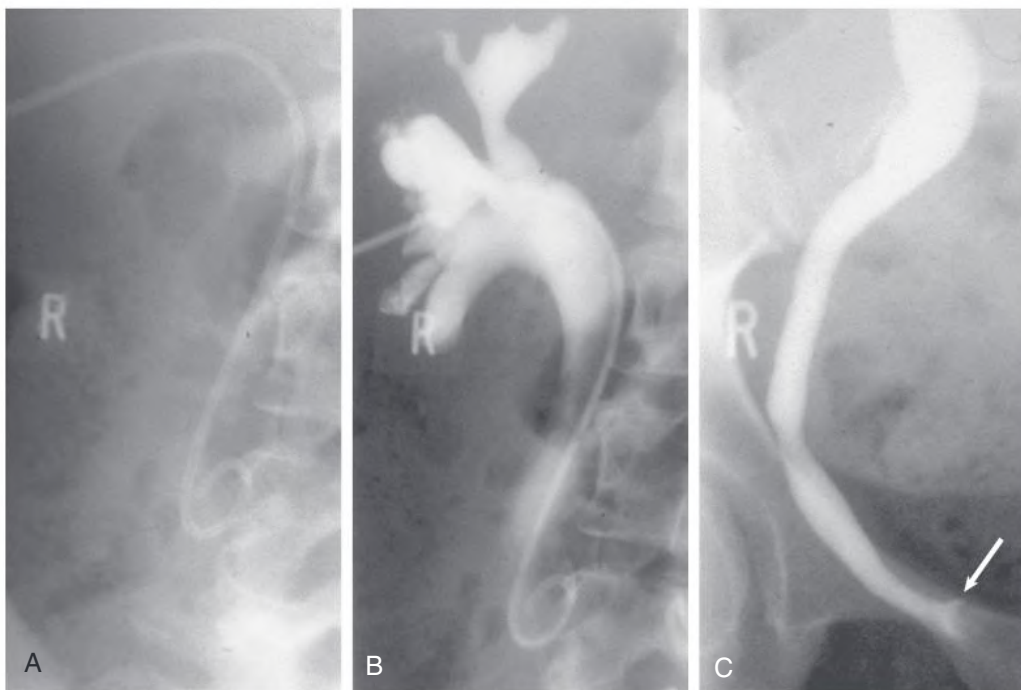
Nephrostogram. A nephrostomy has been placed percutaneously into the dilated collecting system of the kidney under ultrasound control (A). After infusion of contrast material down the nephrostomy, the dilated pelvicalyceal system and upper ureter (B) and the lower ureter (C) are outlined. The ureter is dilated along its length but tapers abruptly at the vesicoureteral junction (*arrow*). In this case the obstruction was caused by a radiolucent stone.
